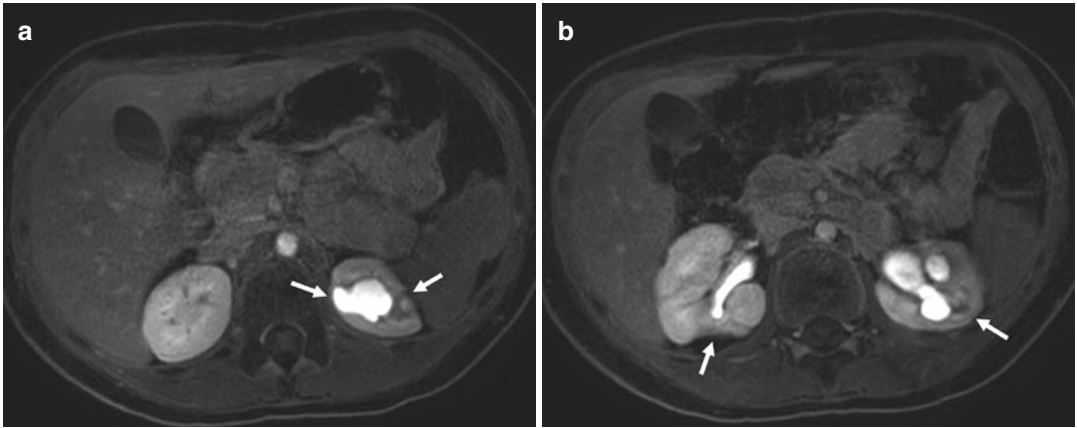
A 10-year-old boy with left hydroureteronephrosis and recurrent pyelonephritis. (a and b) Axial post-contrast T1-weighted fat-suppressed MR images show bilateral areas of renal parenchymal thinning, consistent with multifocal scarring (arrows)
